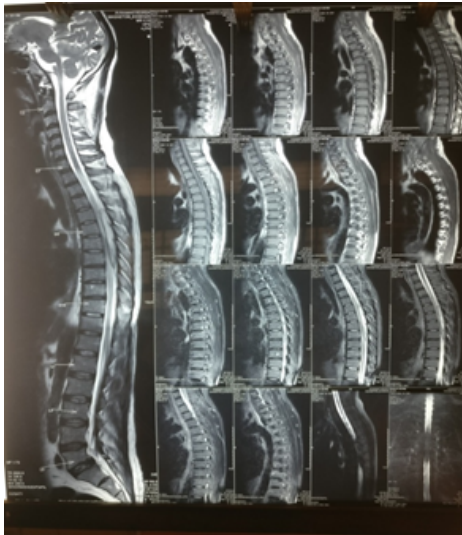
MRI Spine sagittal section - pyriiform shaped SEA extending from D4 to D8 vertebrae.
